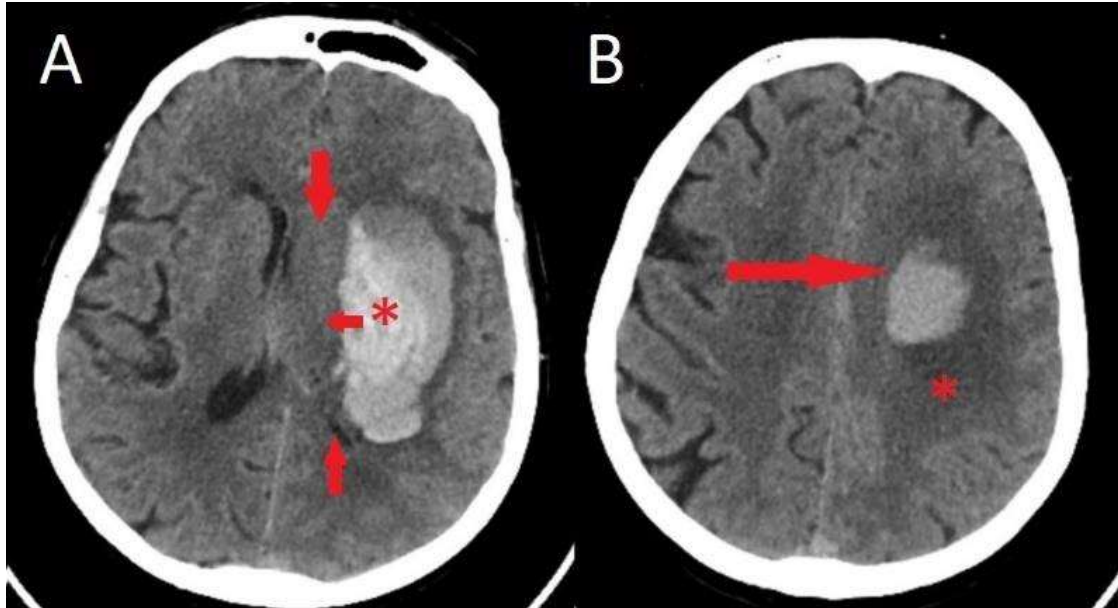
Non-enhanced CT scan of a patient with an acute ICH. A spontaneously hyperdense, heterogeneous lesion with hematic densities, at the level of the left insular cortex and internal capsule (Image A, *) compressing the basal nuclei and lateral ventricle (Image A, arrows), extended subcortically in the frontotemporal region, the left corona radiata and ipsilateral semioval centrum (Image B, arrow), with a mass effect, shifting the midline with about 9 mm. Perilesional edema with a thickness of up to 10 mm surrounds the hematoma (Image B, *)
